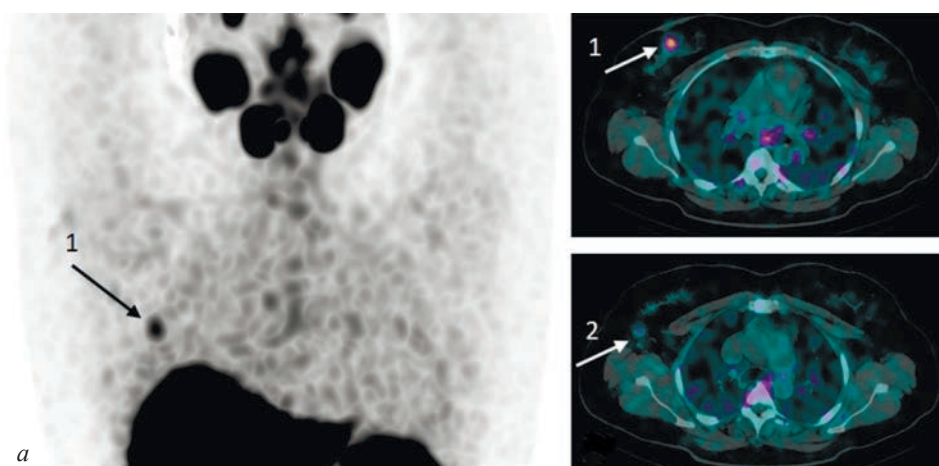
MIP- reconstruction (a) and combined SPECT/CT images (b) at 2 h after administration of [$^{99\text{m}}\text{Tc}$]Tc-HYNIC-PSMA in a patient with BC, metastasis to the axillary lymph node: 1 – breast tumor, SUVmax 5.1; 2 – enlarged lymph node, SUVmax 1.93 (self-reported)
